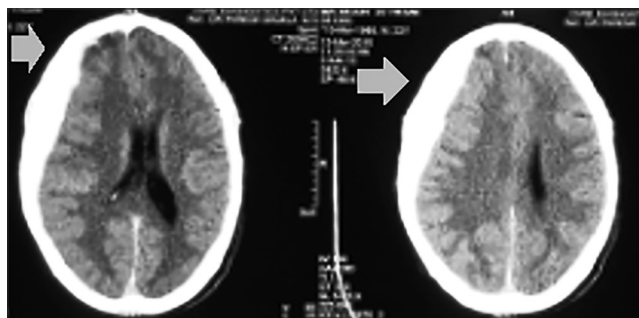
Computed tomography scan of patient with arrow showing location of sub dural hematoma
